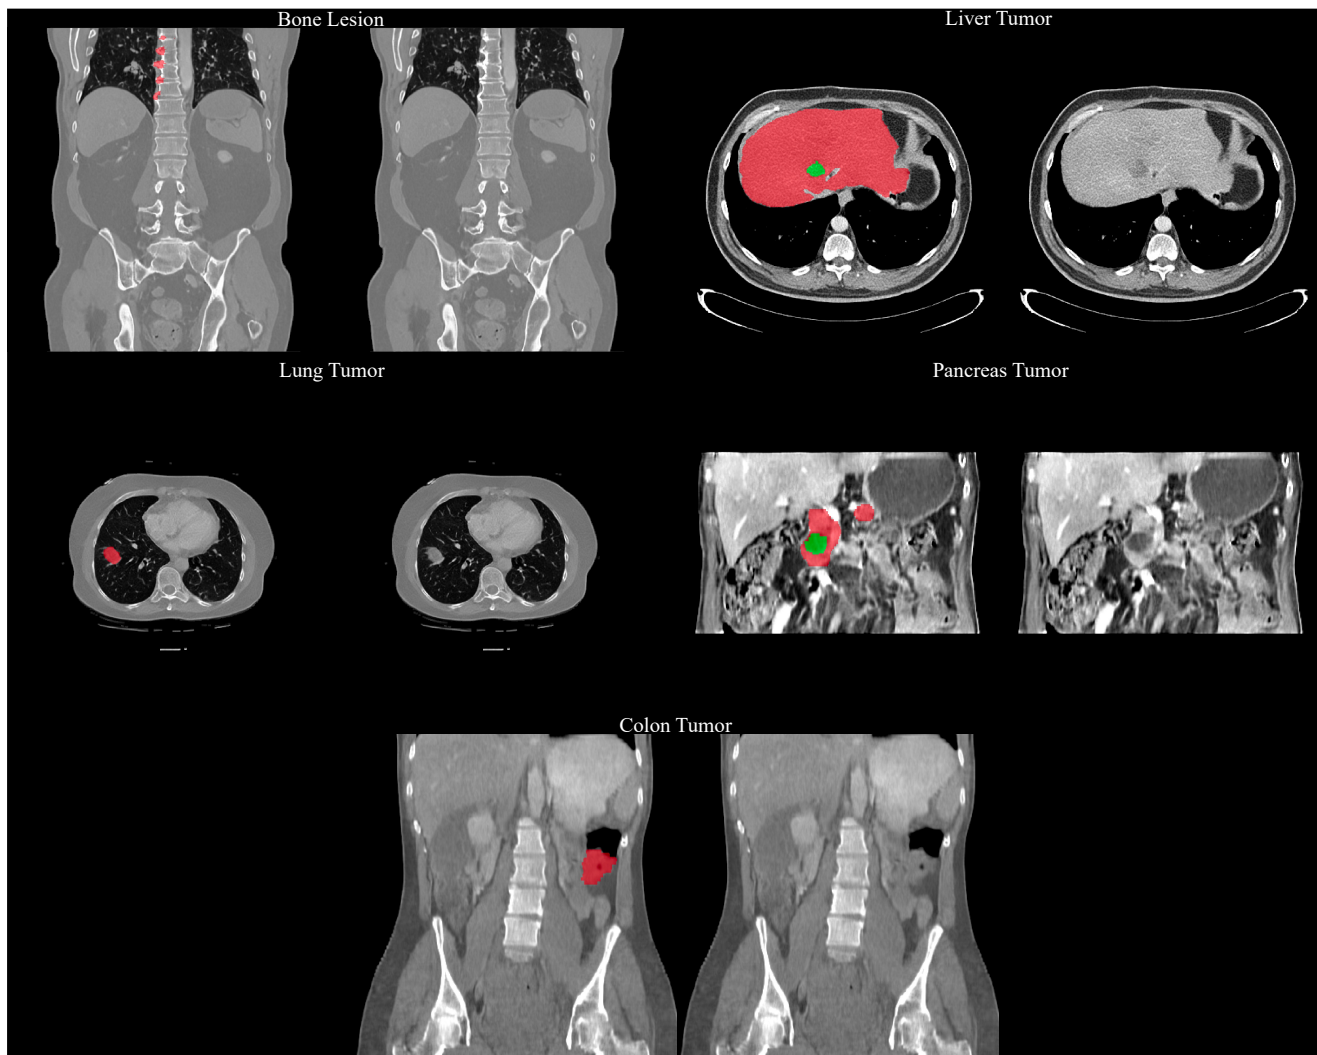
The example of generated images from MAISI CT Generation task.
